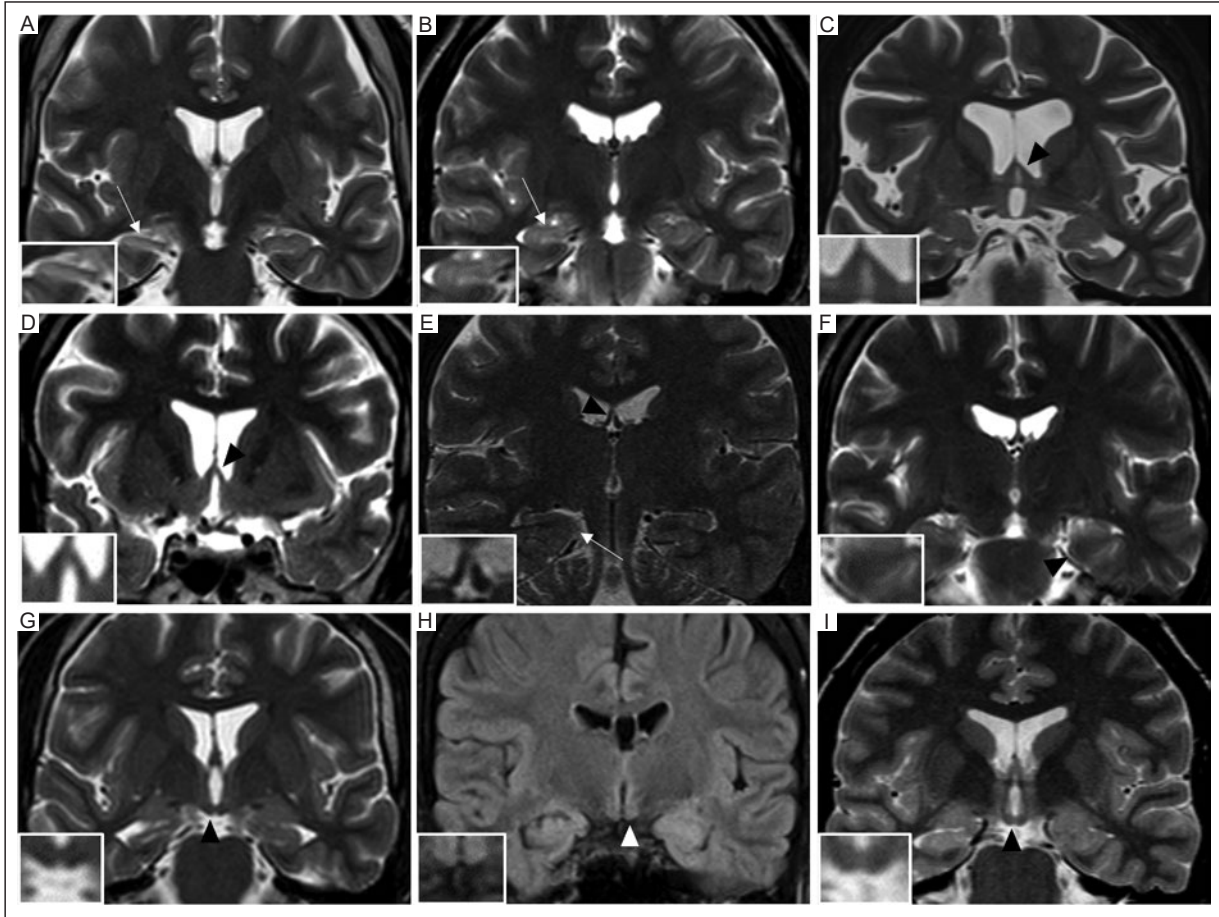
Examples of other abnormal findings on a preoperative structural MRI of patients with refractory TLE. Magnified views are shown. A: coronal T2-weighted view of a 34-year-old man with a loss of hippocampal head digitations in the right hippocampus (arrow). B: coronal T2-weighted view of a 21-year-old man with a loss of hippocampal head digitations in the right hippocampus (arrow). C: coronal T2-weighted view of a 37-year-old woman with atrophy of the left fornix (black arrowhead). D: coronal T2-weighted view of a 39-year-old man with atrophy of the left fornix (arrowhead). E: coronal T2-weighted of a 29-year-old woman with a loss of grey-white matter differentiation in the temporal lobe (black arrow) and atrophy of the right fornix (black arrowhead). F: coronal T2-weighted view of a 35-year-old man with a loss of grey-white matter differentiation in the left temporal lobe (black arrowhead). G: coronal T2-weighted view of a 21-year-old man with atrophy of the right mammillary body (black arrowhead). H: coronal FLAIR view of a 44-year-old woman with atrophy of the left mammillary body (black arrowhead). I: coronal T2-weighted view of a 21-year-old man with atrophy of the right mammillary body (black arrowhead). MRI: magnetic resonance imaging; TLE: temporal lobe epilepsy; T2: weighted turbo-spin-echo sequence; FLAIR: fluid-attenuated inversion recovery.
